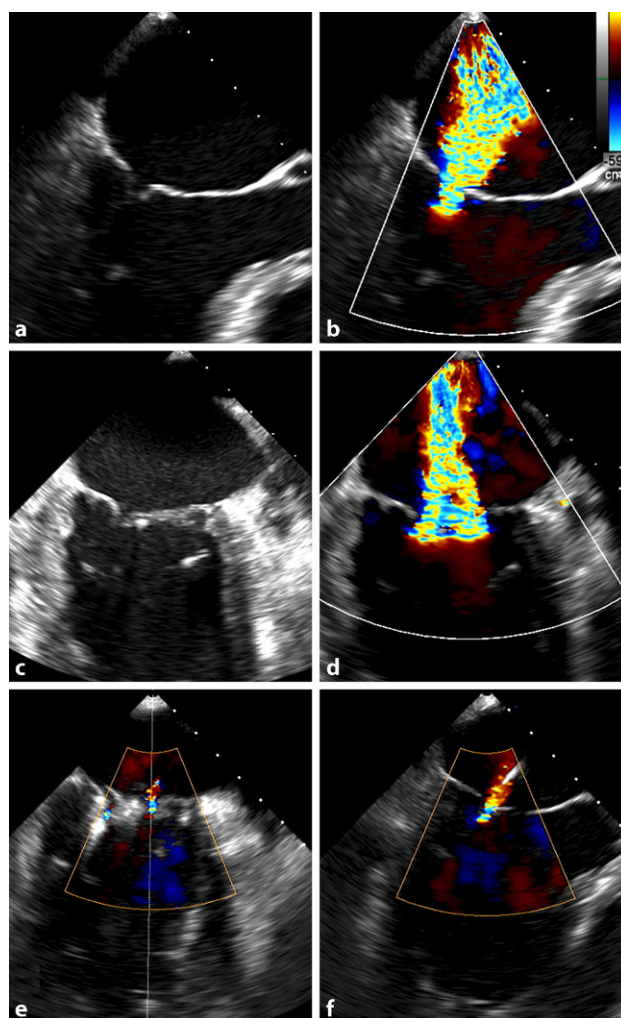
Transesophageal echocardiography in patient No. 1 with secondary (ischemic) mitral regurgitation and a favorable anatomy before (long axis view without (a) and with (b) color Doppler flow, intercommissural view without (c) and with color (d) Doppler flow) and immediately after MitraClip implantation with successful reduction of the regurgitant jet (e intercommissural view, f long axis view)
